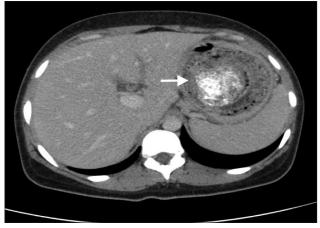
(A) Computed tomography scan of the abdomen, showing a gastric trichohezoar.
